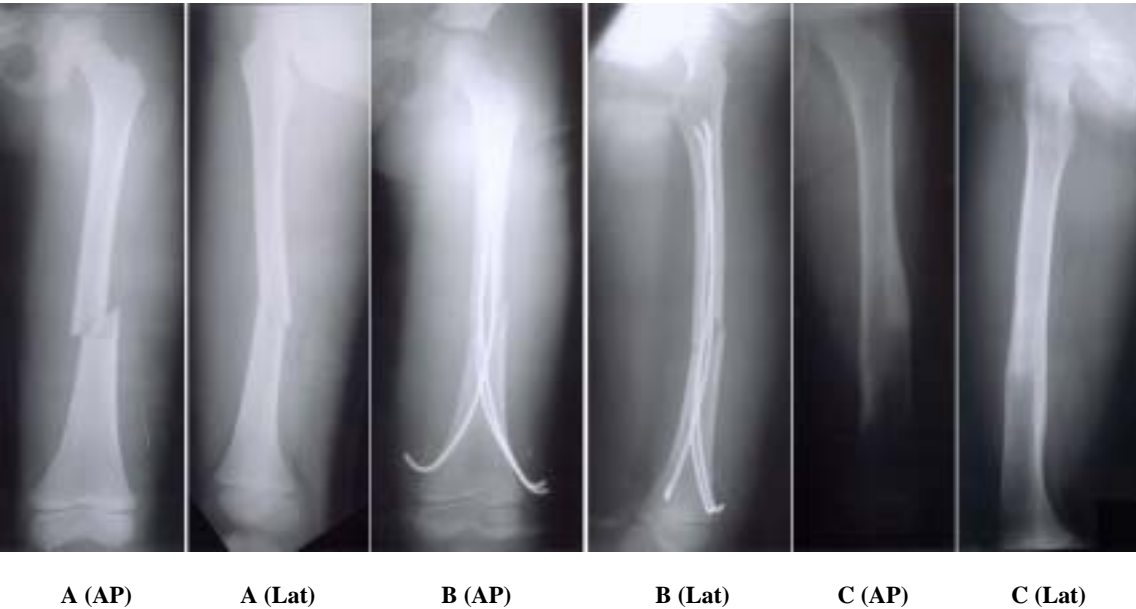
Serial radiograph of 9 year old boy treated by Nancy nail.
